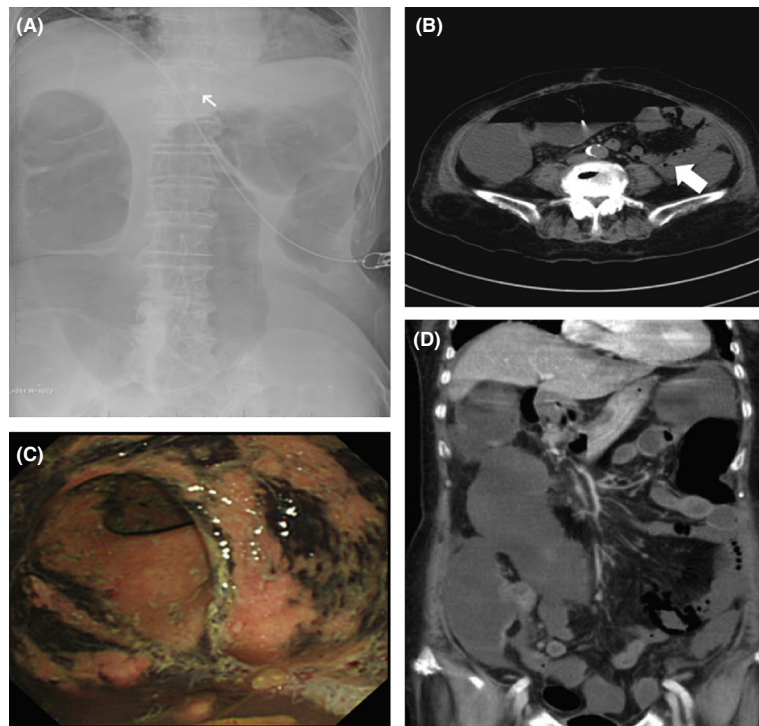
(A) A plain abdominal X-ray showed air-filled and dilated colon loops as the sign of paralytic ileus. (B) Abdominal noncontrast computed tomography (CT) scan showed intestinal segments dilated and distended by air-fluid levels, resulting in paralytic ileus and diffusely involving small bowel loops with pneumatosis intestinalis (arrow). (C) The colonoscopic examination revealed a focal area of pale and edematous mucosa interspersed with petechial hemorrhage and superficial ulceration on the recto-sigmoid colon. (D) A reformat CT image showed a reduced number of vessels in the mesentery of the bowel loops.
